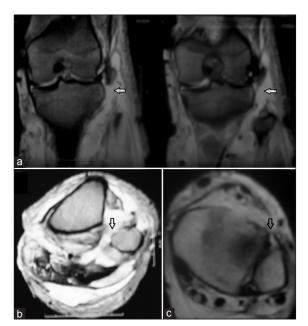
MRI of (Lt) knee showing (a) Complete disruption of the proximal tibiofibular ligament and the lateral collateral ligament. (White arrows) (b) Disruption of the interosseus ligament. (c) Sprain of the anterior tibiofibular ligament of the distal syndesmosis. (Arrow) Note the slackness of the ligament and edema
